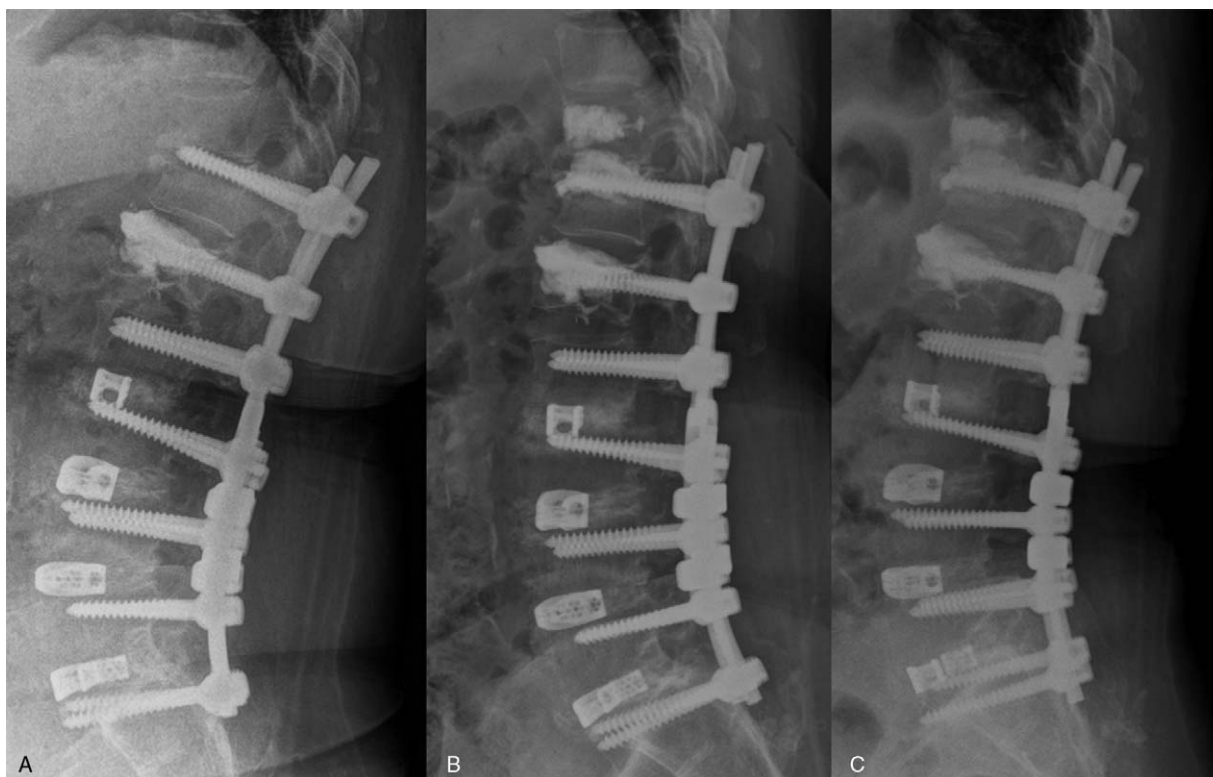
A 70-year-old woman with proximal junctional failure after posterior lumbar interbody fusion (case 4). (A) T11 proximal junctional fracture with penetration of T12 superior endplate by superior pedicle screw (case 4) revealed on X-ray. (B) Percutaneous cement injection was performed at the level of the T11 vertebral body and the T11-T12 disc space. (C) The thoracolumbar collapse showed minimal progression at the last follow-up.
